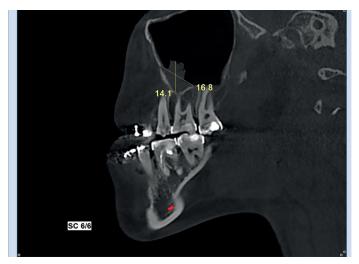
Sagittal CBCT image of the fungus ball in the right maxillary sinus
